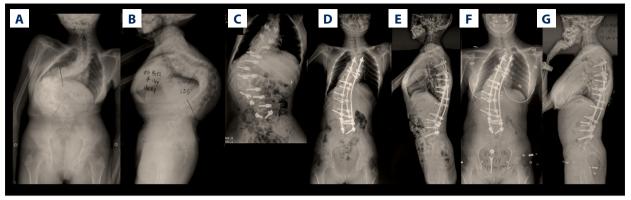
The posteroanterior (PA) and lateral X-ray images of the spine in a 14-year-old girl with severe kyphoscoliosis. A 14-year-old girl with severe kyphoscoliosis (A, B). The patient underwent posterior spinal release, halo-femoral traction (C), and second-stage posterior spinal fusion. Following surgery, the coronal and sagittal deformities were significantly corrected (D, E). The correction was well maintained at a four-year follow-up (F, G).
